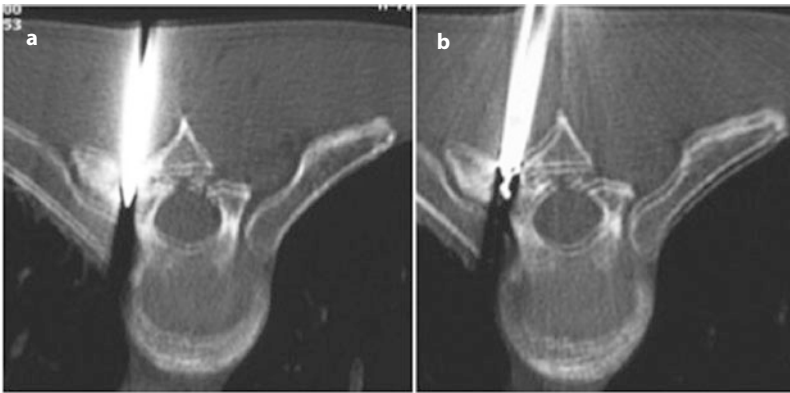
Bone sampling during percutaneous radiofrequency ablation for an osteoid osteoma. CT-guided positioning of the needle (a) and its final position (b)
